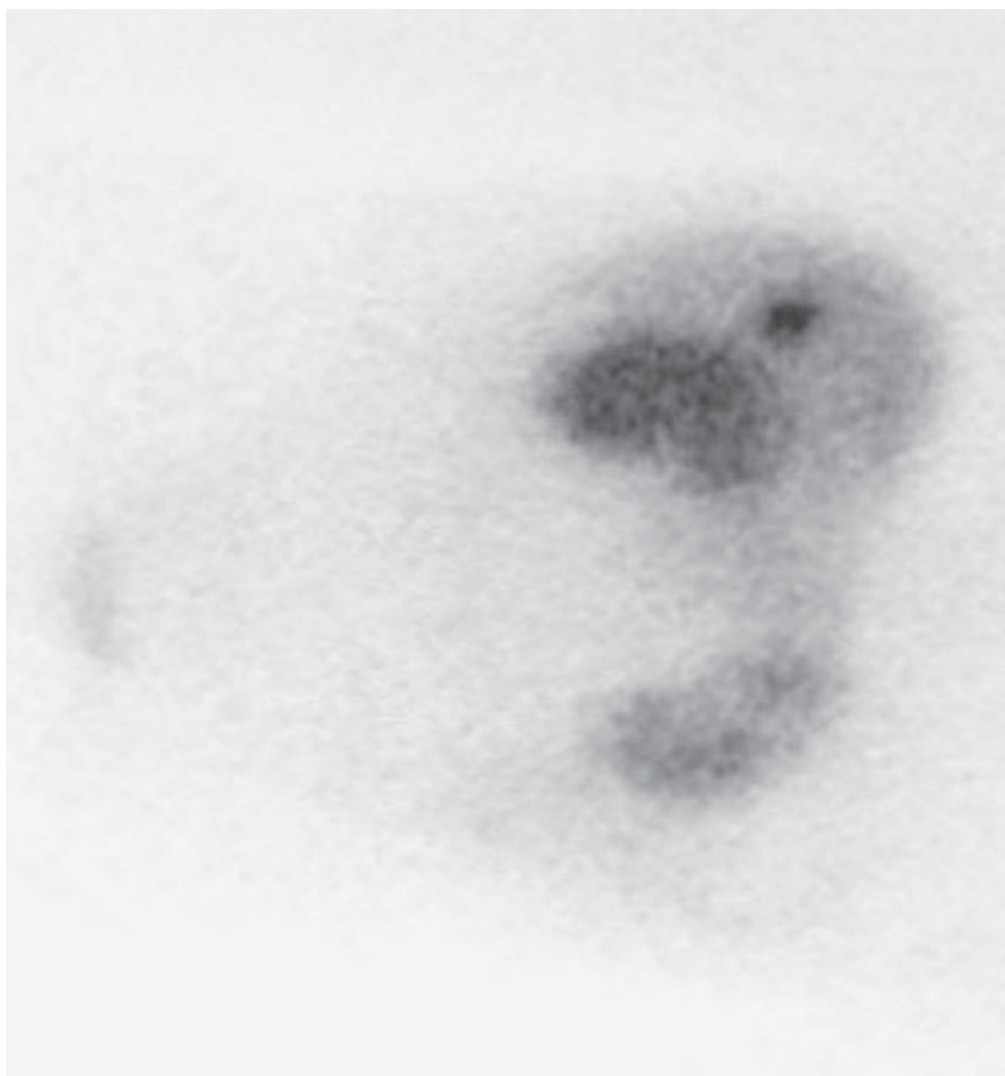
This solitary liver metastasis of a nonfunctioning islet cell cancer was detected by somatostatin receptor imaging. It was treated by percutaneous radiofrequency ablation under CT guidance.
